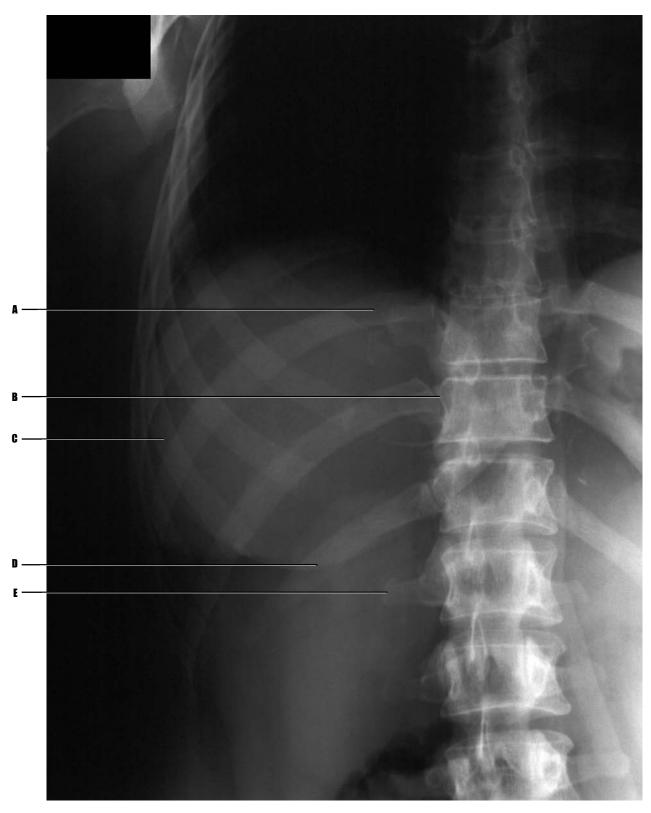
Adult patient, plain film radiograph, "rib view" of posteroanterior right chest.
